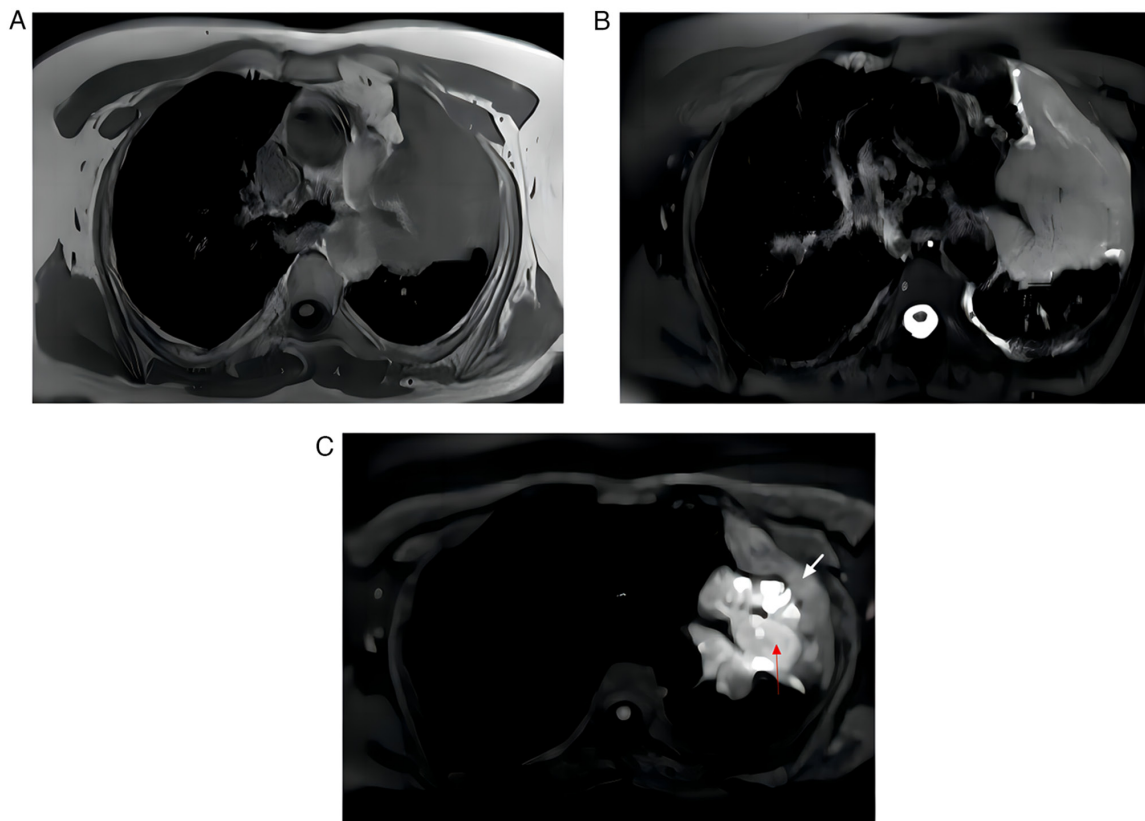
Magnetic resonance imaging sequences of a 61-year-old female patient with a central lung cancer accompanied with atelectasis. (A) Images from T1 sequence. (B) Images from T2 sequence. (C) Images from DWI sequence. DWI can differentiate tumor (red arrow) from atelectasis (white arrow), and tumor in DWI sequence had a clearer margin than those in T1 and T2 sequences. DWI, diffusion weighted imaging.
